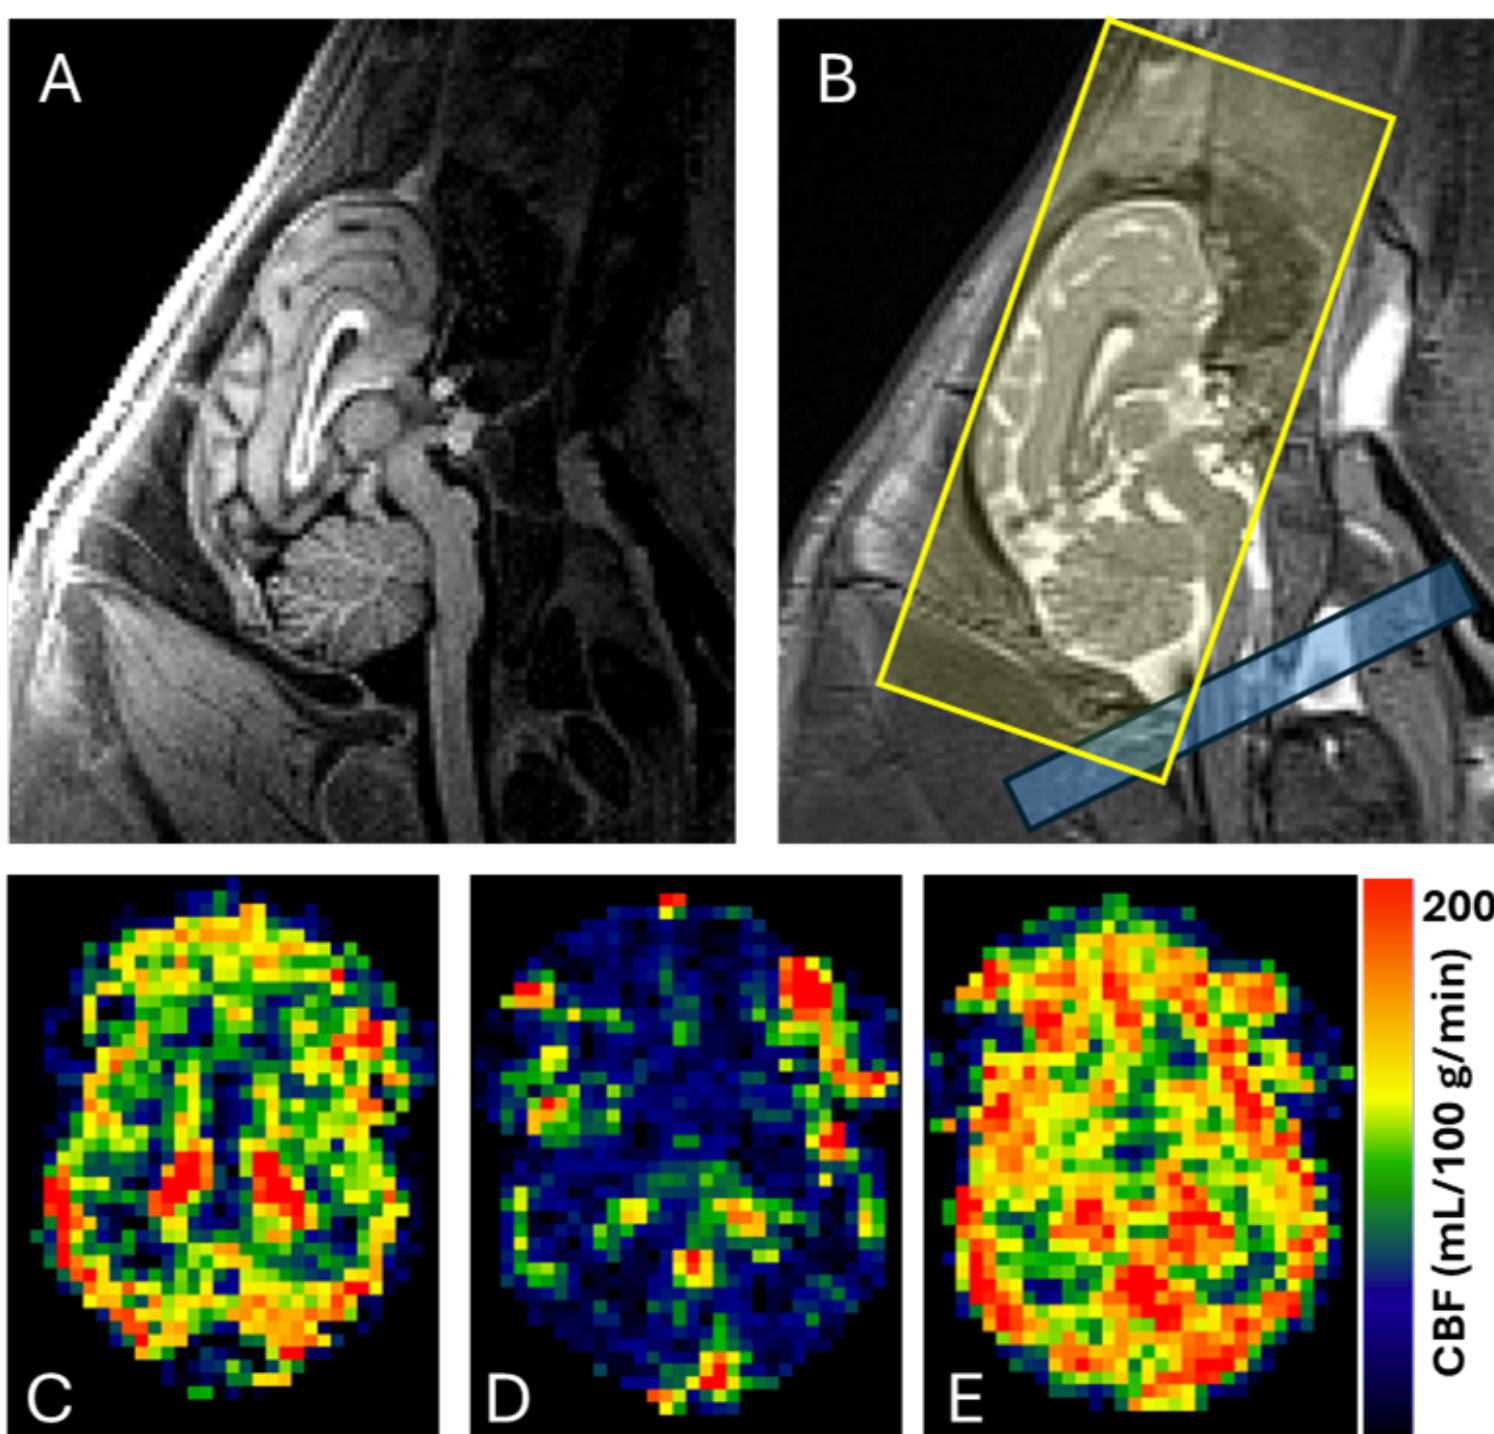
Representative HUP-CPR anatomic and perfusion MRI: Anatomic T1-weighted (A) and T2-weighted (B) anatomic imaging series. Panel (B): the blue box indicates the location where blood is magnetically labeled for the ASL studies and the yellow box indicates the multi-slice imaging volume. The perfusion imaging maps of one mid-brain axial slice are shown at baseline (C), 1h post (D) and 4h post ROSC (E).
